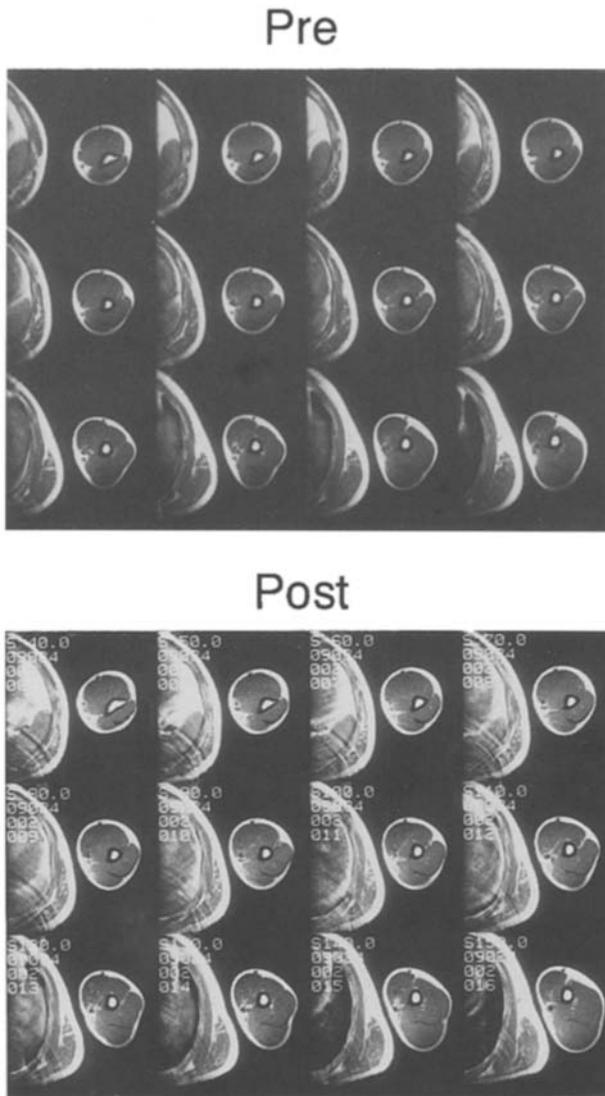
Series cross-sectional magnetic resonance images of the upper extremity before (*Pre*) and after (*Post*) training for one subject. The scanning was carried out from the elbow joint to the head of humerus, with a slice thickness of 10 mm. In this figure, images including the middle portion of the triceps brachii muscle are shown, from the *top left* to the *bottom right*
